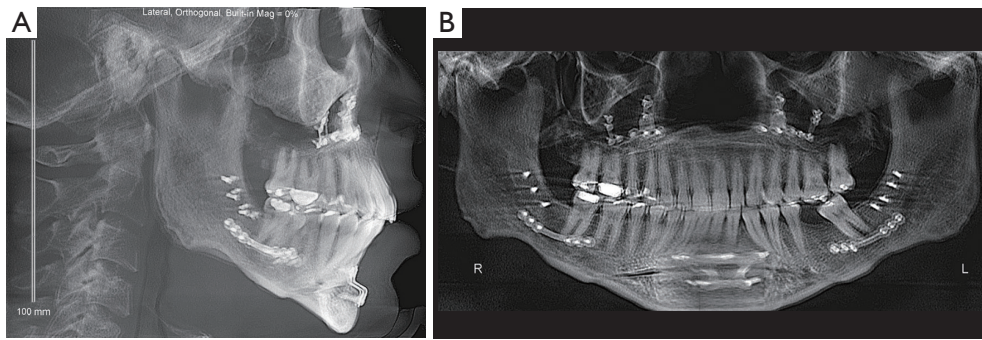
Post-treatment (A) lateral cephalogram and (B) panoramic radiograph.
